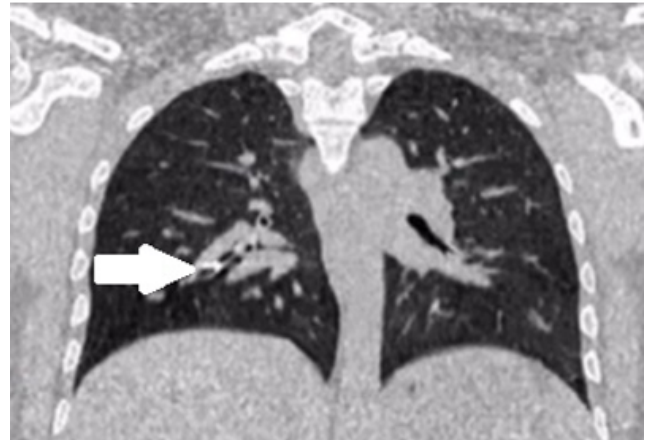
HRCT of the thorax (Sagittal view). White arrow indicating the FB in the bronchus intermedius.
